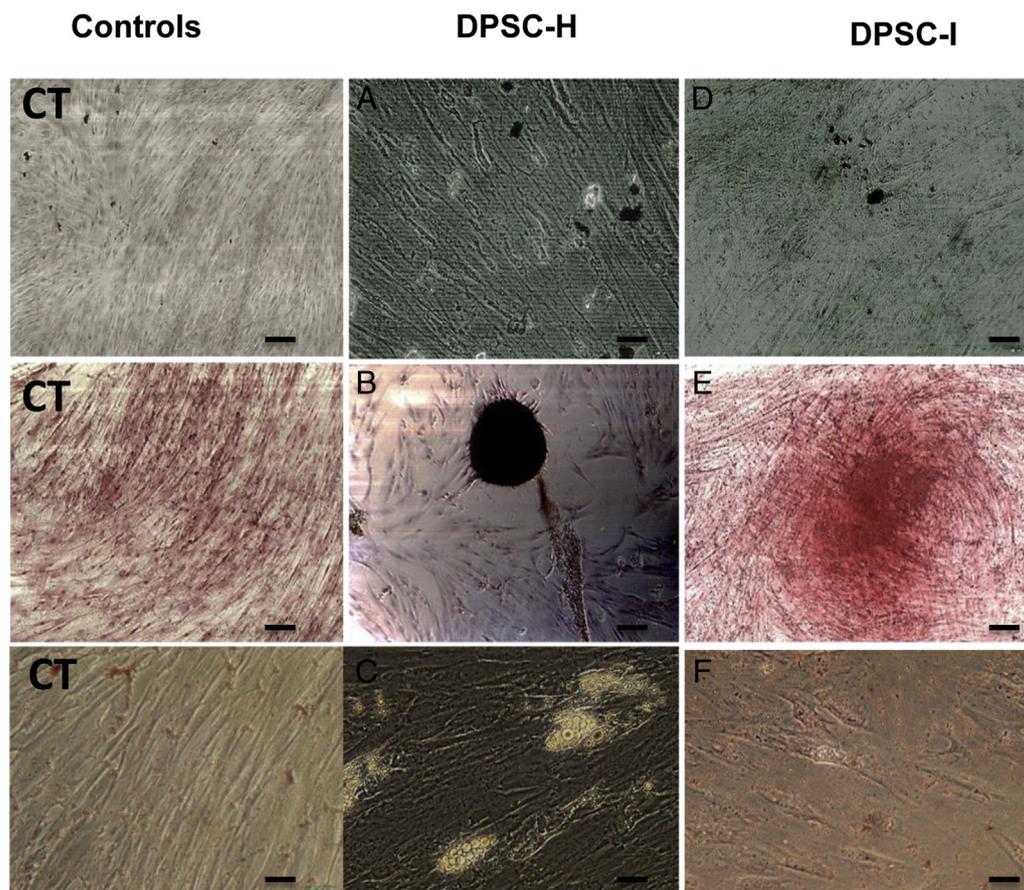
DPSC trilineage differentiation. DPSC-H and DPSC-I were cultured in the absence (controls) or presence of differentiation media culture as described in the Materials and Methods section. DPSC controls (CT), (A–C) DPSC-H, and (D–F) DPSC-I for osteogenic, chondrogenic, and adipogenic differentiation, respectively. Magnification 10×, bar = 100 μm.
